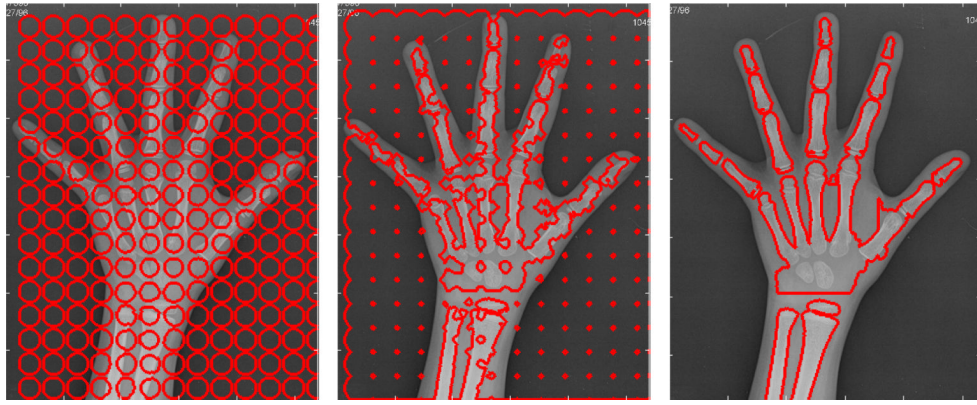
Initial, intermediate and final contour for the segmentation of bones on the sample radiograph.
